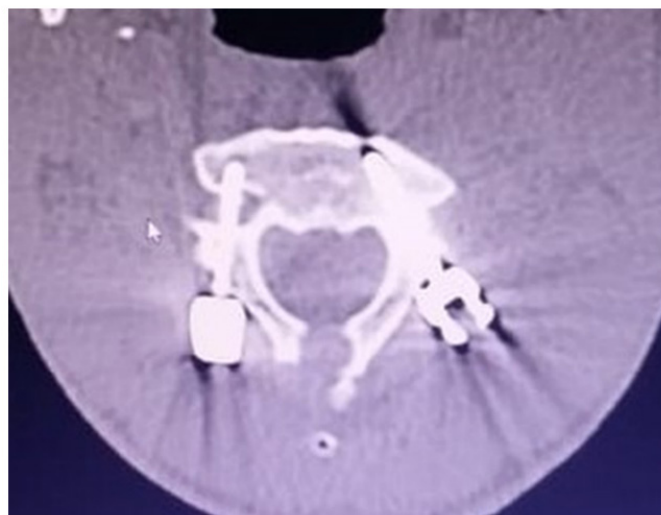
Axial postoperative CT image of the of cervical spine representing C2 pedicle screw had severely violated right transverse foramen with right vertebral artery injury.
